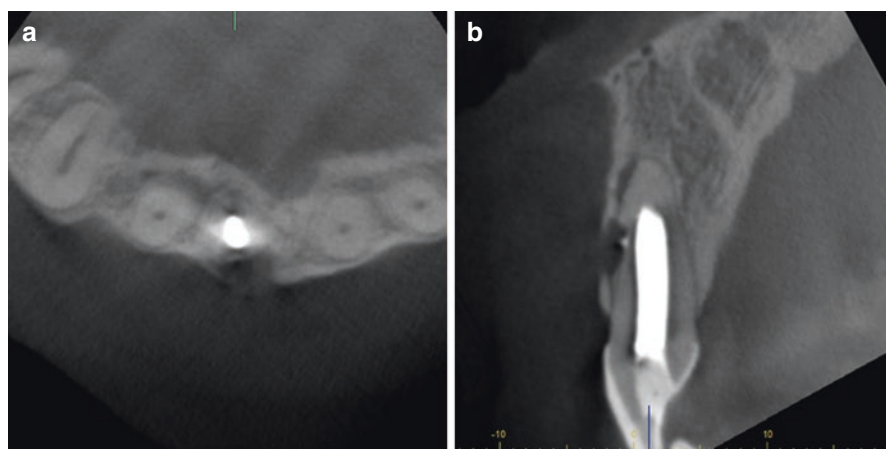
CBCT images depicting external resorption and periradicular bone loss associated with tooth #8 causing a labial cortical defect. (a) Axial view and (b) cross-sectional view
